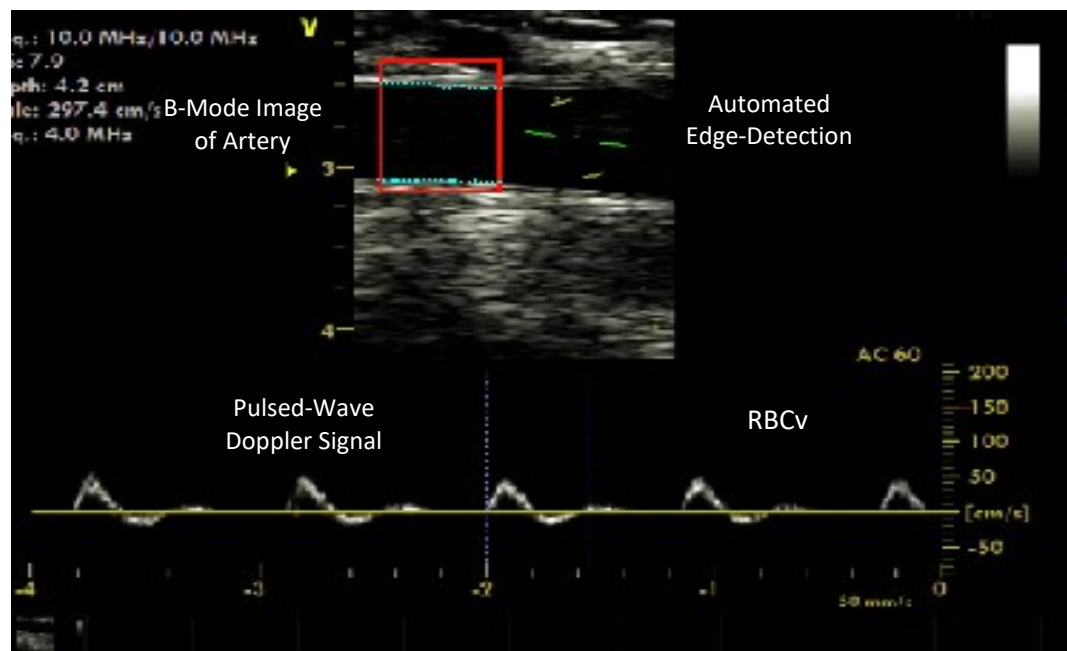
Example of the information observed from high-resolution duplex ultrasound imaging using both B-mode imaging and pulsed-wave Doppler signals. B-mode, brightness mode; RBCv, red blood cell velocity.
